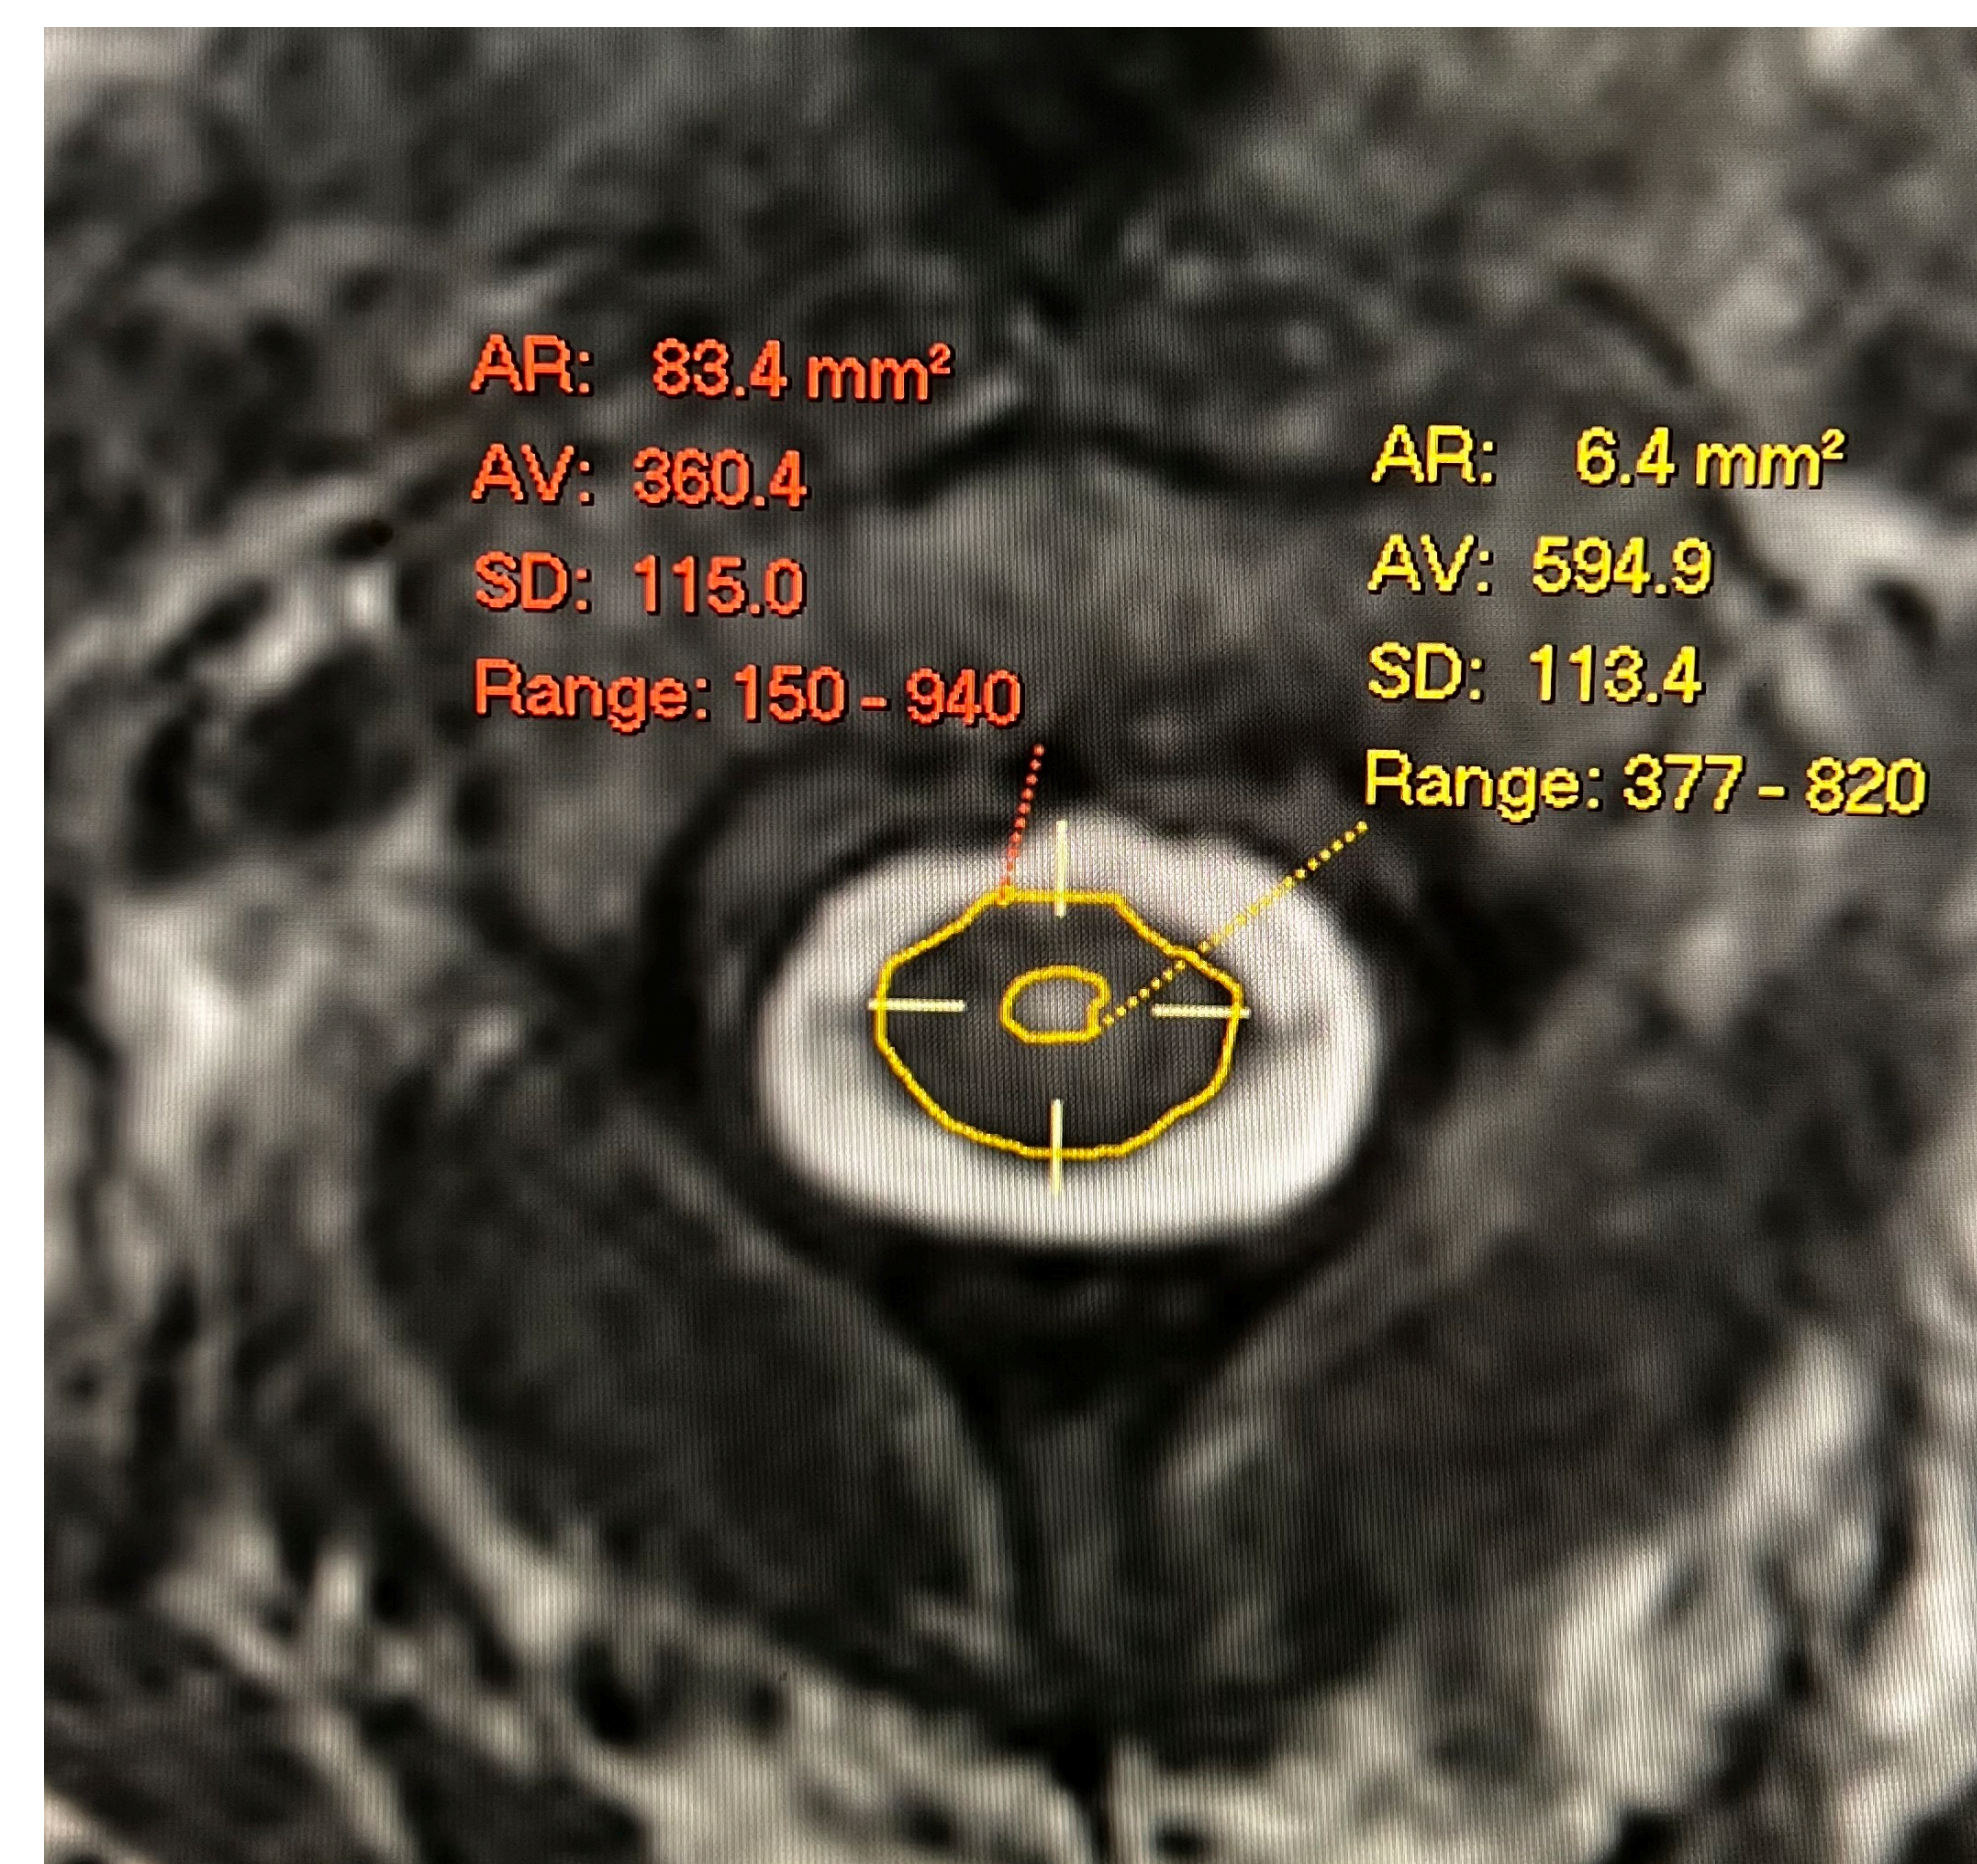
T2-weighted axial scan of a spinal cord with syrinx was manually measured.
